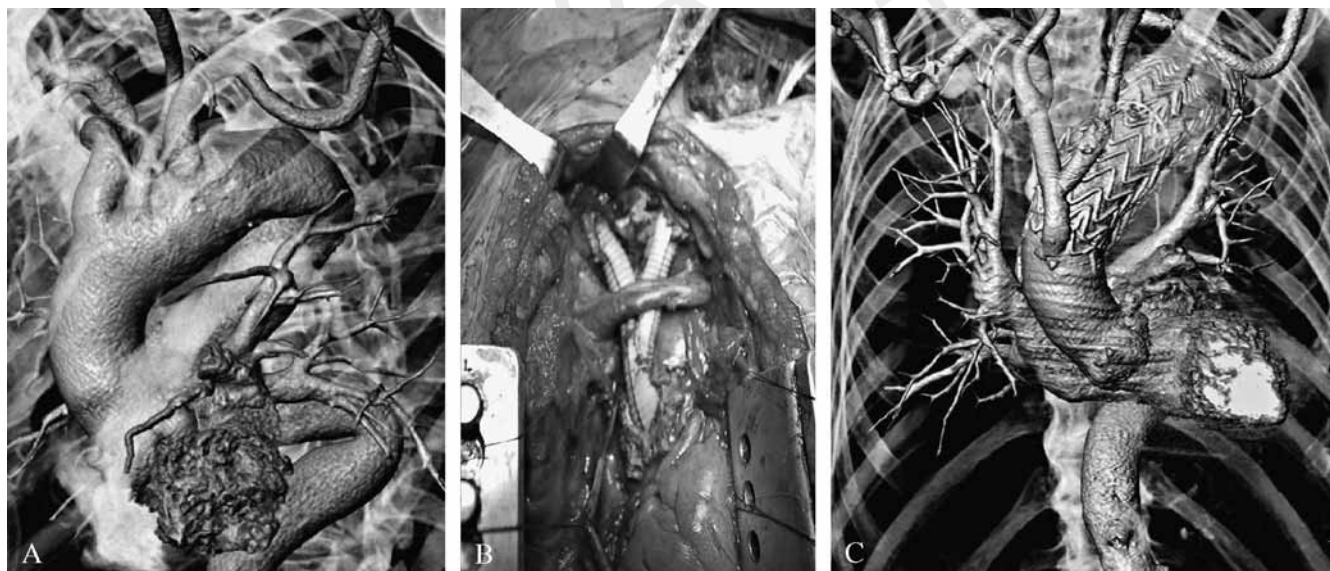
An aortic arch aneurysm involving zone 0: A) preoperative evaluation, B) intraoperative image, C) CT scan at discharge.
